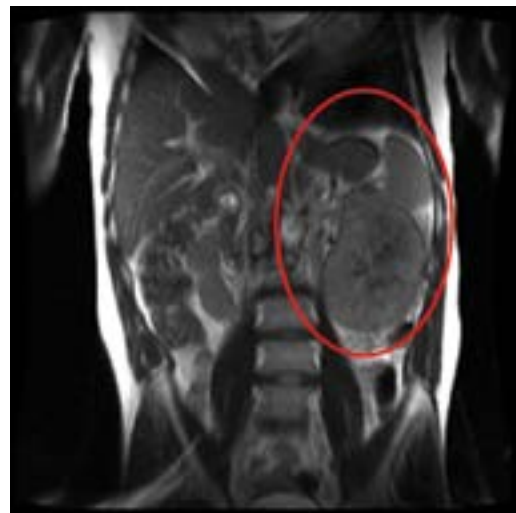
Magnetic resonance image of the presenting left renal mass. This mass measured approximately 14.6 × 9.6 × 13.0 cm.
